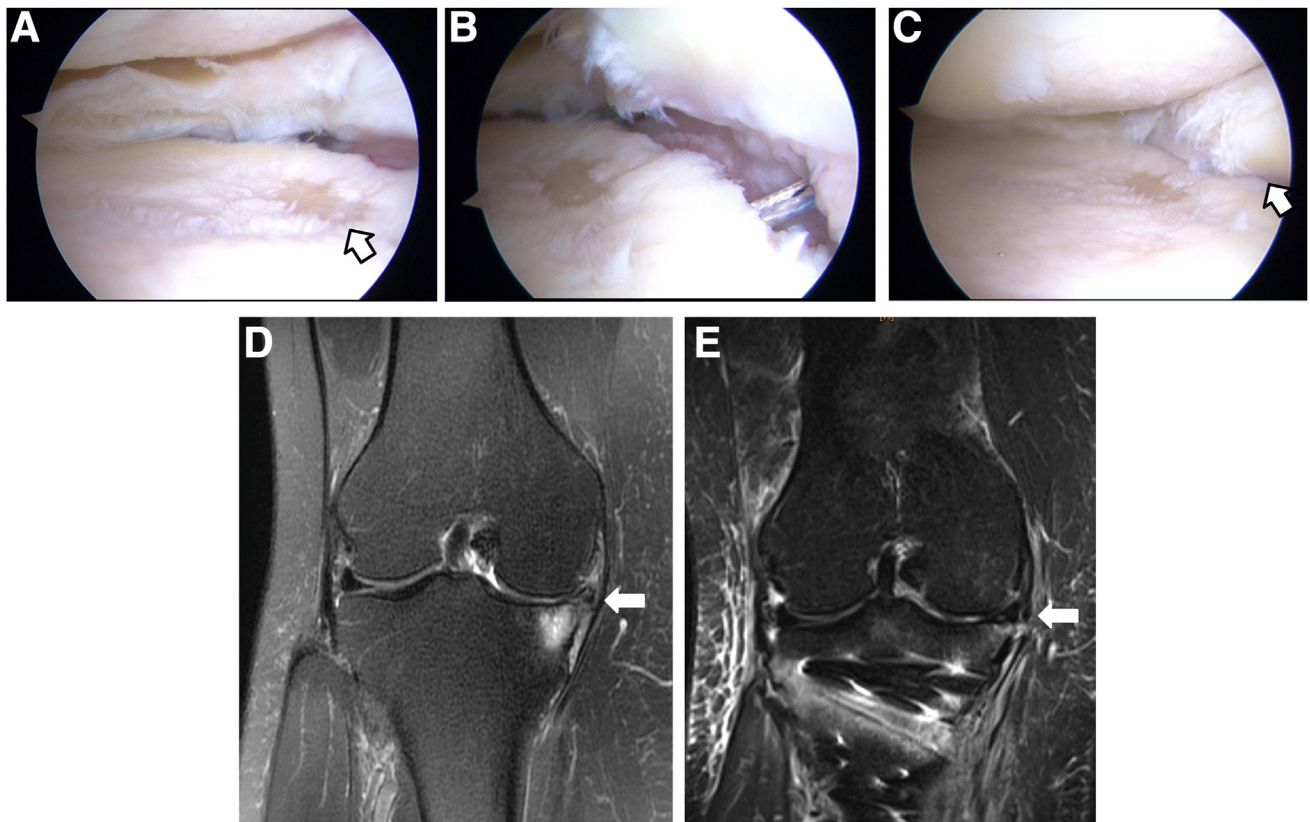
Arthroscopic view of right knee from anterolateral portal and magnetic resonance images in 58-year-old female taekwondo player. (A) Degenerative tear of medial meniscus and full-thickness chondral defect of medial tibial condyle (arrow). (B) Appearance before suture relay. (C) After suture relay, the meniscotibial capsule is reattached to the tibia (arrow). The medial meniscus is centralized once the procedure is complete. (D) Coronal T2-weighted fat-suppressed (FS) magnetic resonance image at initial presentation showing findings indicative of extruded degenerative tear of medial meniscus (arrow). (E) Coronal short inversion time inversion recovery (STIR) magnetic resonance image at 2 weeks after surgery. The medial meniscus is centralized (arrow) once the procedure is complete.
